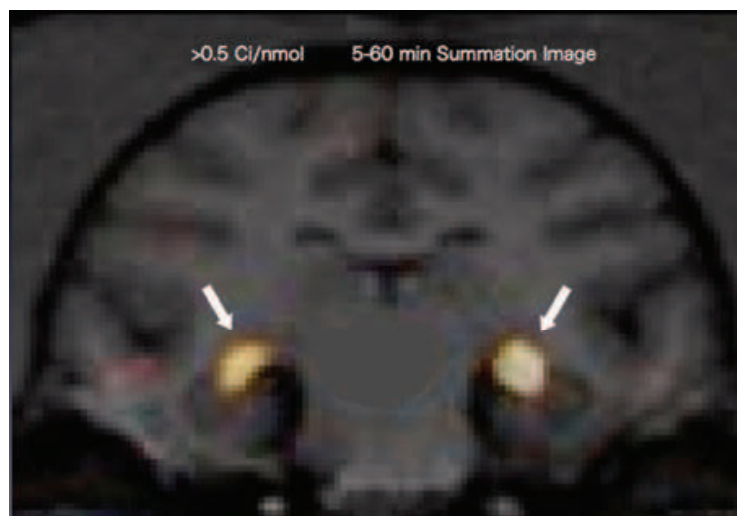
Accumulation of [^{11}C]PK11195 activity in the LGN. A PET summation image is superimposed on an MRI T1 image. The PET image in the frontal plane shows selective accumulation of activity in the LGN of both hemispheres (arrows). Modified from NeuroReport, (Imamura et al., 2009)
